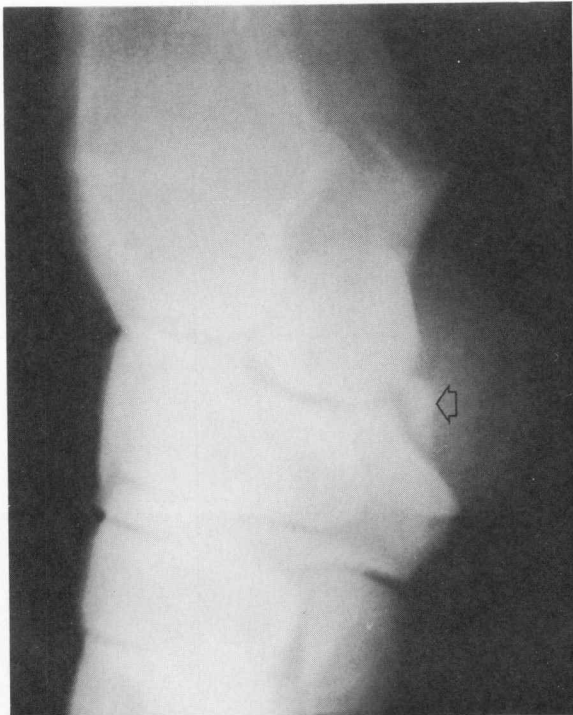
Dorsomedial-palmarolateral oblique radiograph made at 75° medial to the DPa projection. Fracture is easily found (arrow).
